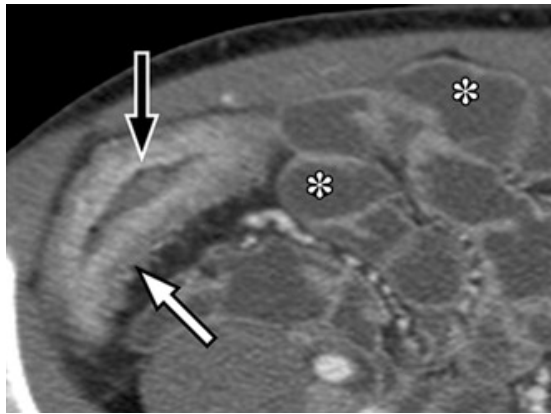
(Axial CT enterographic section shows mucosal hyperenhancement (black arrow) and mural stratification (white arrow) of the terminal ileum, an appearance that contrasts markedly with that of non-diseased ileal segments).
